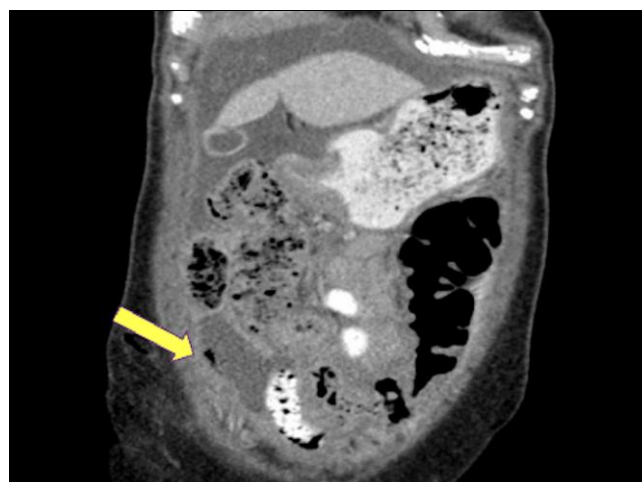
CT abdomen and pelvis with oral and IV contrast. The arrow indicates a focus of free air in the right lower quadrant, which grew in size compared to the IV contrast only study. Lack of oral contrast extravasation supports that the perforation is contained.
